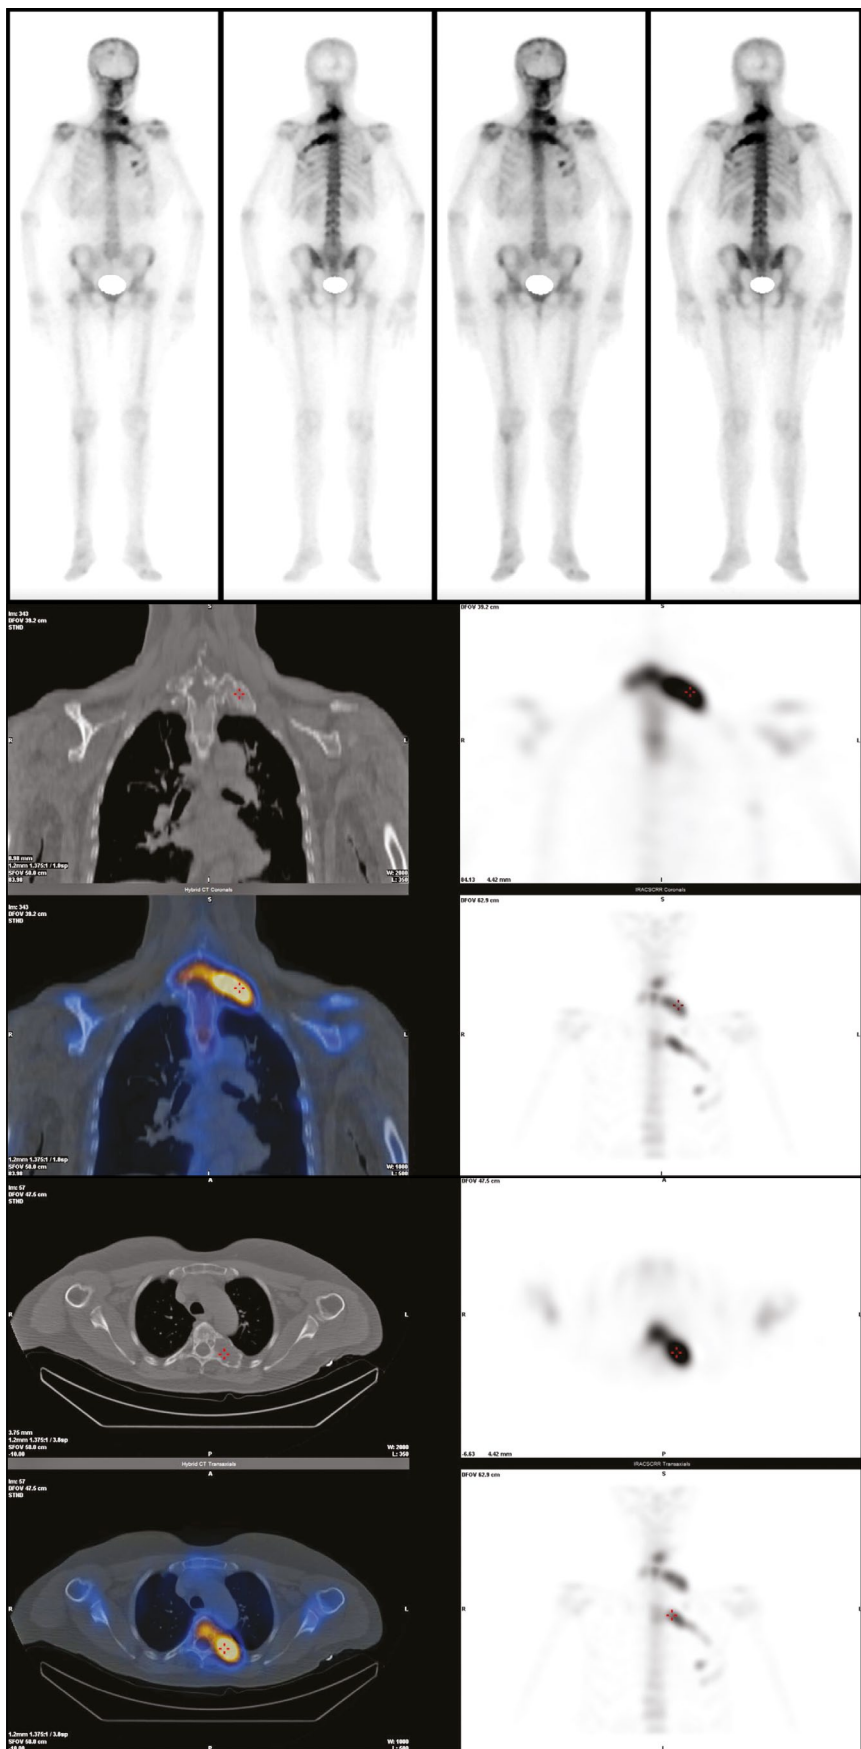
The whole body SPECT-CT confirmed the involvement of the above-mentioned bone segments and no other particularly shows two areas of high pathological focal accumulation of the osteotropic tracer (99mTc-HDP) in the left paravertebral side (D1 and D5-fifth left rib).
